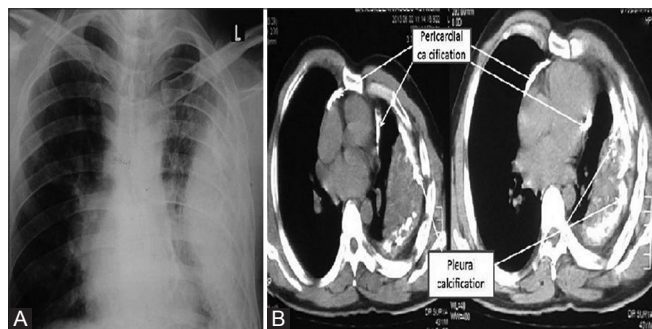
Panel A-Chest X-ray posteroanterior view showing heterogeneous opacity due to pleural thickening and calcification. Panel B-Computed tomography images demonstrating pericardial and pleural calcification (White arrows)
